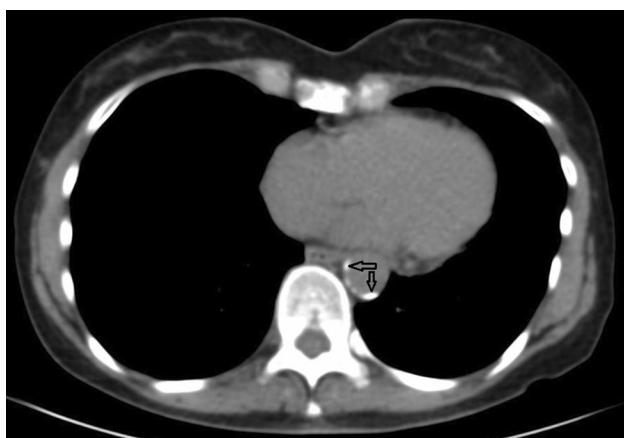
Axial slice of a CT scan showing calcification (arrows) in the descending aorta comprising between 25 and 50% of the vessel wall circumference indicating a calcification score of 2
